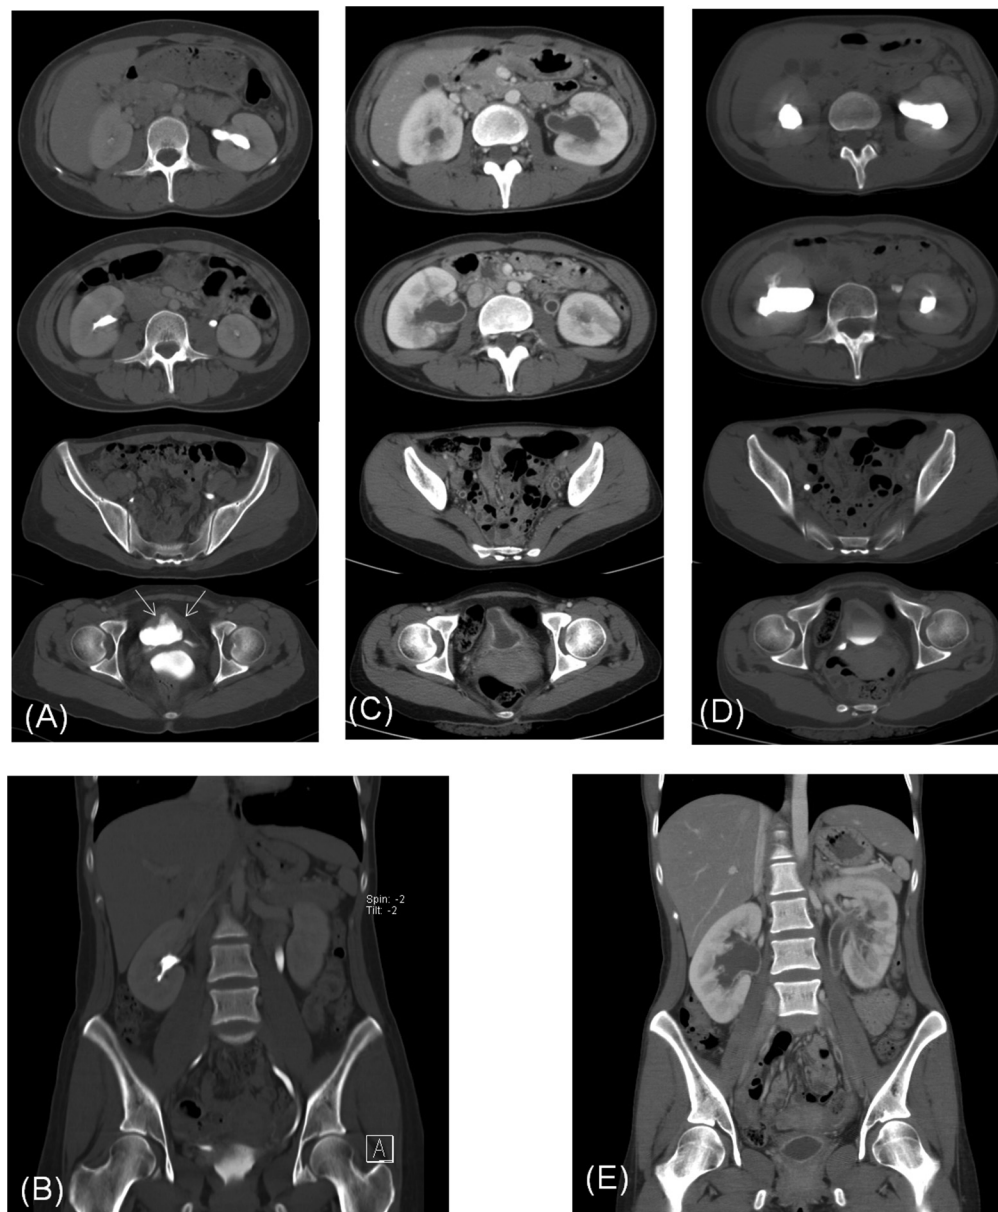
CTU study of a 24-year-old woman with a 2-year history of ketamine abuse. (A) Sequential axial post-contrast images and (B) coronal reconstruction image of a split-bolus CTU study. The axial images of the combined nephrographic and excretory phase reveal bladder wall thickening (arrows) and a small bladder volume. There is no hydronephrosis or hydroureter. (C–E) Three-phase CTU exam after 6 months [(C) nephrographic phase, (D) excretory phase, and (E) coronal reconstruction of nephrographic phase] demonstrates diffuse strong mucosal enhancement of renal pelvis and ureters (C, E), hydronephrosis, and hydroureter, indicating rapid disease progression and upper urinary tract involvement by ketamine-induced uropathy. CTU = computed tomography urography.
